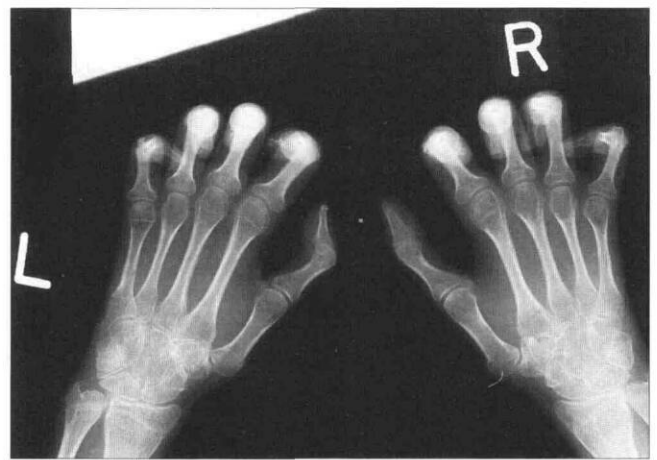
Radiograph of the subjects' hands demonstrates: a) Pip joint flexion contractures, b) multiple lesion of calcinosis and, c) resorption of tip of distal phalanx of let thumb and ulnar styloid. Note the patient was extending her digits as much as possible during this view.
